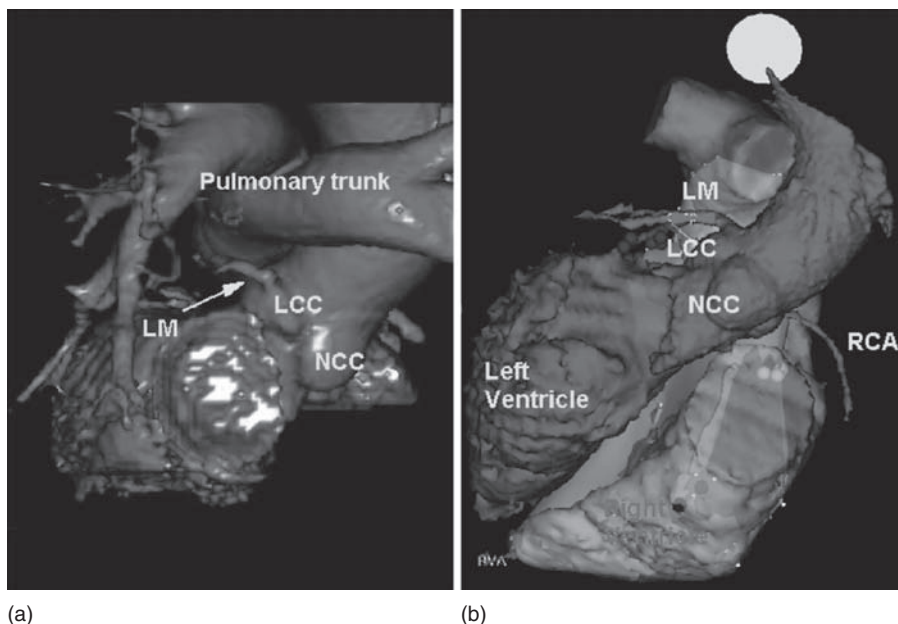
(a) PA view of the heart model generated by 3D reconstruction of cardiac CT. (b) PA CARTO-Merge view of the heart showing the RVOT in relation to the left main (LM) and the right coronary artery (RCA). (See color plate section.)
